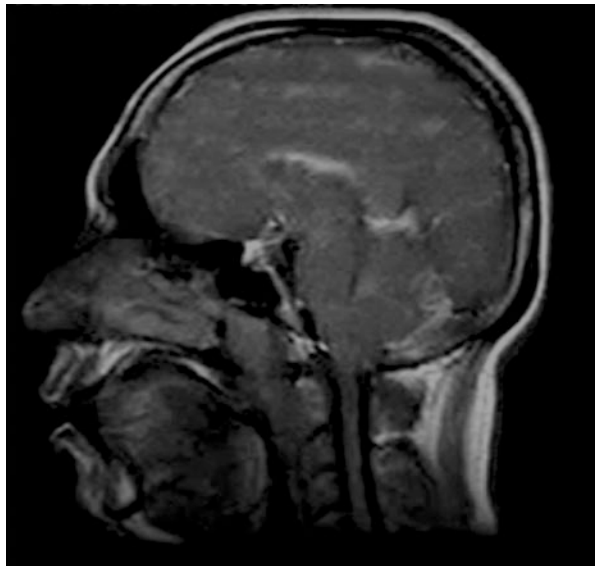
Dynamic MRI of an OSAS patient showing Lingual Tonsillar hypertrophy
